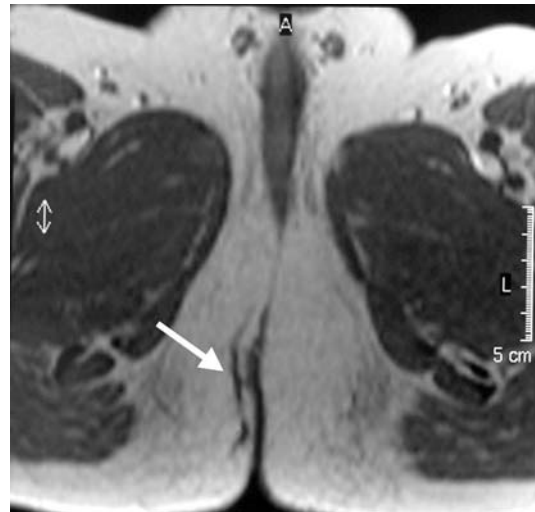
T1-weighted MR image shows an axial plane of a hypointense thin longitudinal lesion being a fistula's track (*arrow*). It is well visible; contrast is present between a low signal intensity track and surrounding hyperintense fat in the right perianal fossa.
